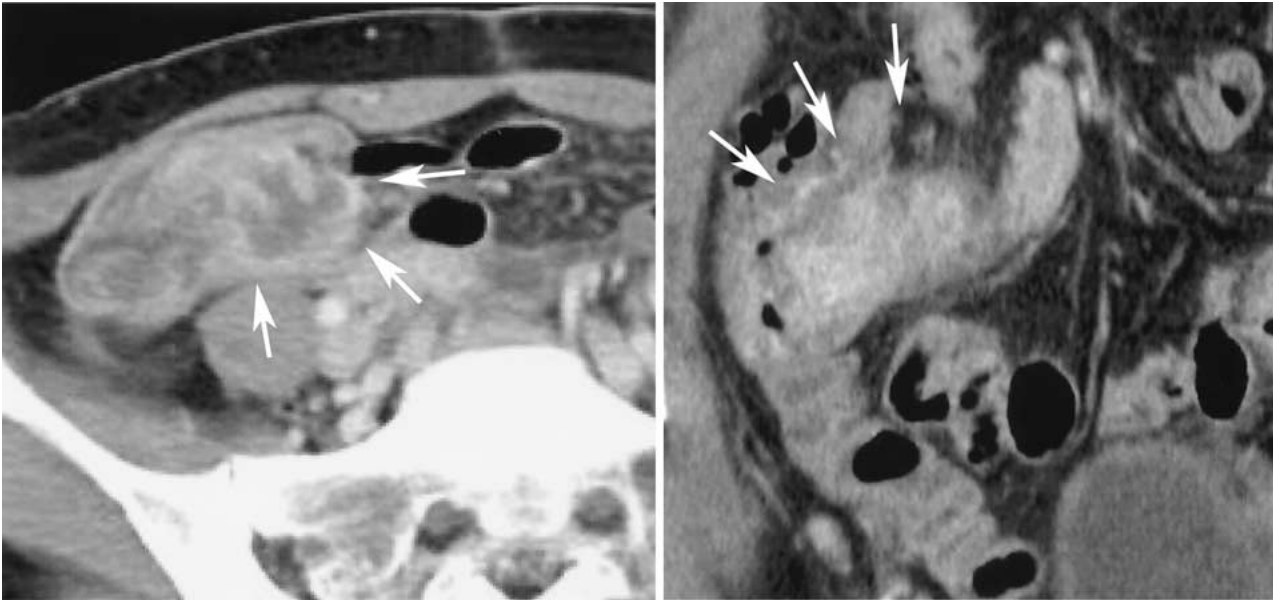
Contrast-enhanced CT image of a perforated appendicitis in (Left) axial and (Right) coronal sections. An inflammatory mass is displayed adjacent to the cecum (*arrows*). The proximal site of the appendix is not identifiable.
